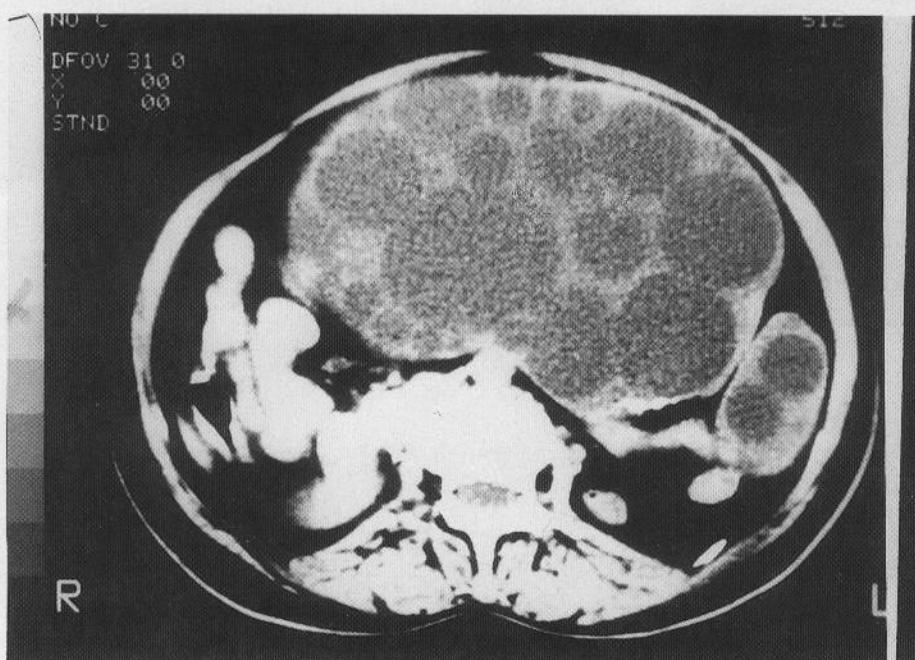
CT scan showing a large multicystic abdominal mass involving the spleen and pancreas.
